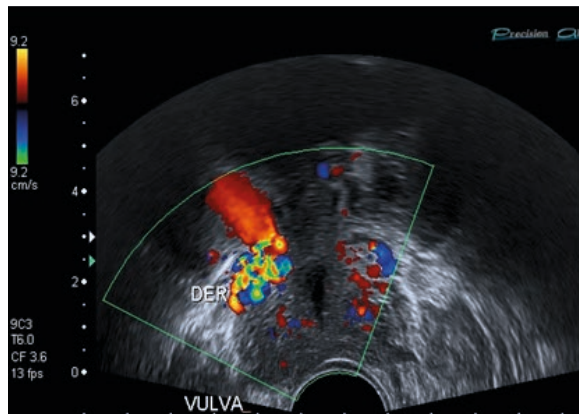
B) TV ultrasound study of the cervicovaginal plexus; the tip of the transducer is at vulvar level in the vaginal introitus. Right reflux from the internal pudendal vein can be seen.
